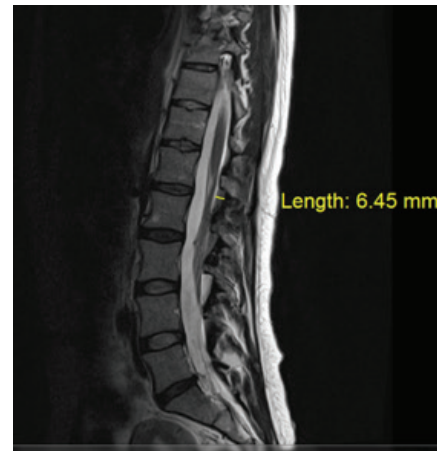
Sagittal T2-weighted LS MRI scan shows acute spinal subdural hematoma from vertebral body L1 to L4.
